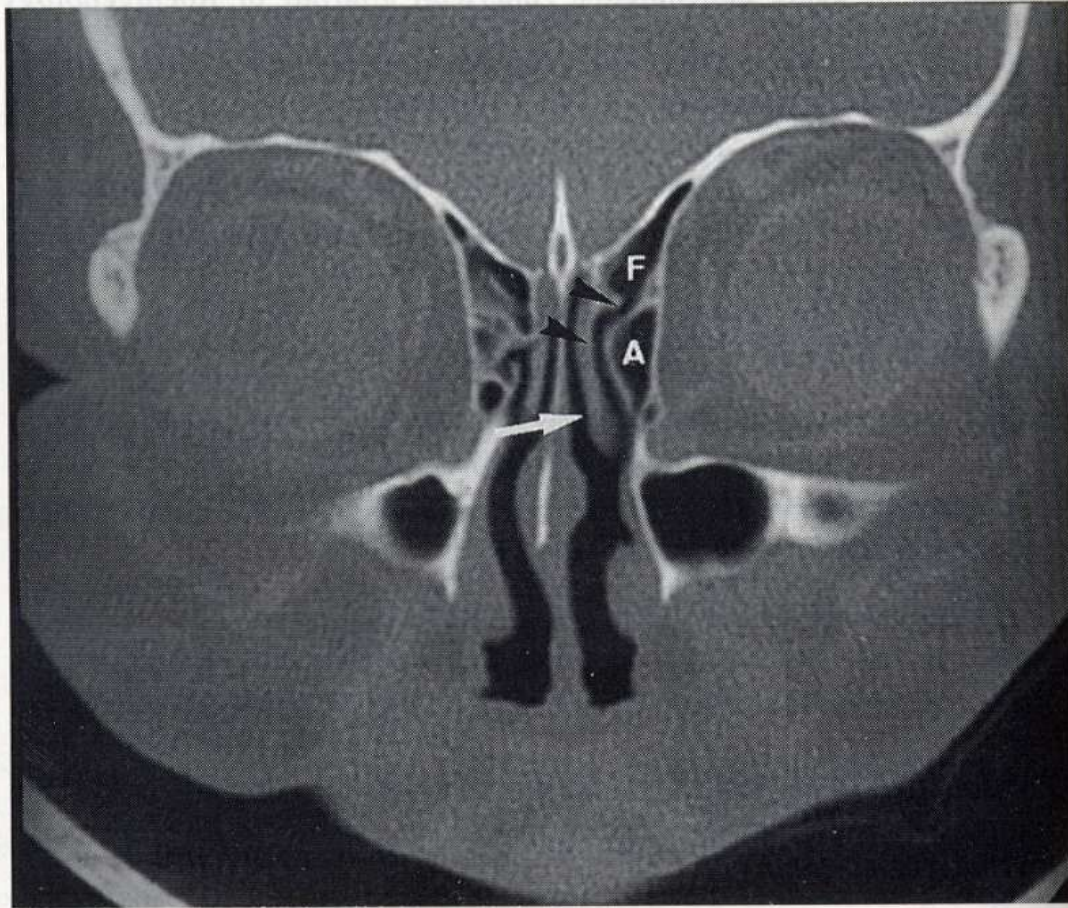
Coronal CT shows the agger nasi cell (A) inferior to the frontal recess (F). Note the frontal recess draining into the middle meatus (arrow-heads). The middle turbinate (arrow) forms the medial relationship of the frontal recess.
